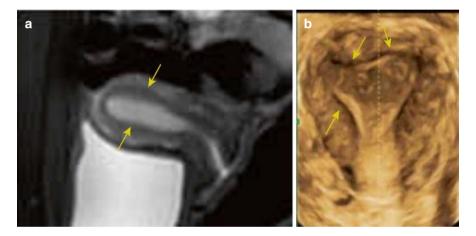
The uterine junctional zone: panel (a) is an MRI image of the uterine junctional zone, and panel (b) is an ultrasound image of the uterine junctional zone
